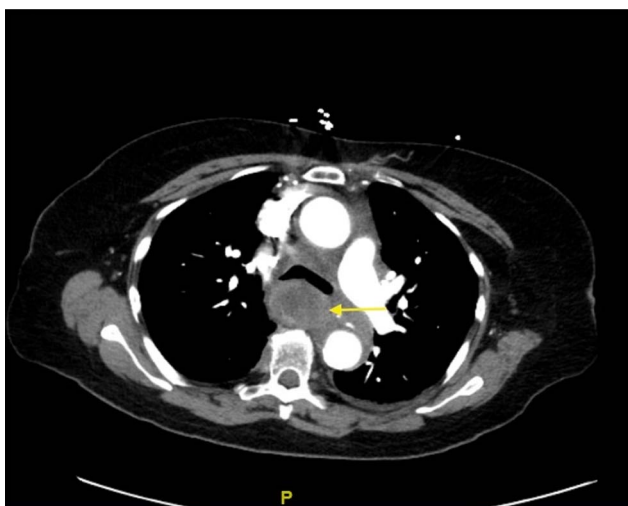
Chest computed tomography with mediastinal mass causing dysphagia.
